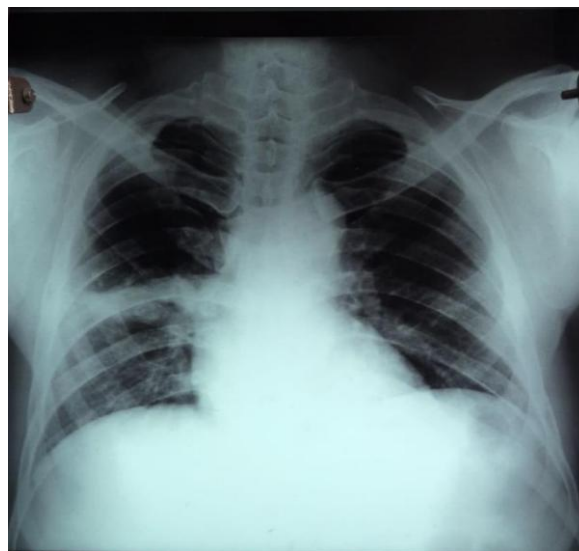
Follow-up chest radiograph showing resolution of right lung consolidation with residual fibrotic bands.
